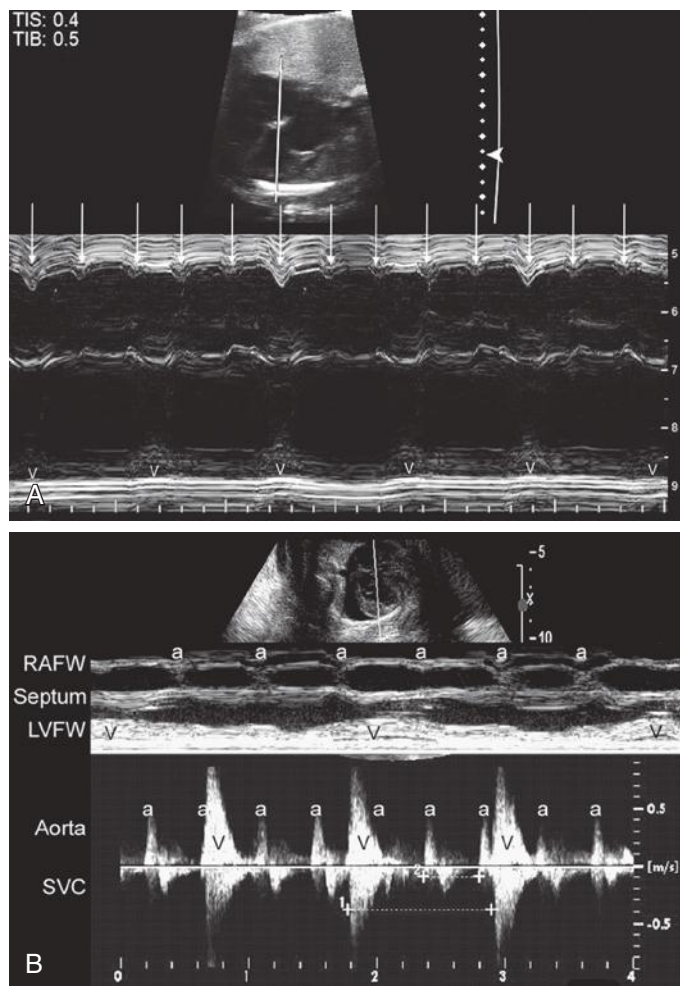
Complete heart block. A, M-mode through the ventricular (below) and atrial (above) walls show that there are many more atrial contractions (arrows) than ventricular contractions (V). The ventricular rate is 52 beats per minute, whereas the atrial rate is 120 to 130 beats per minute. B, Doppler tracing of the superior vena cava (SVC) and ascending aorta (lower panel) showing complete atrioventricular dissociation related to complete atrioventricular block. The atrial rate (a-a) is 140 beats per minute, and the ventricular rate (V-V) is 54 beats per minute. LAFW, left atrial free wall; RAFW, right atrial free wall.
